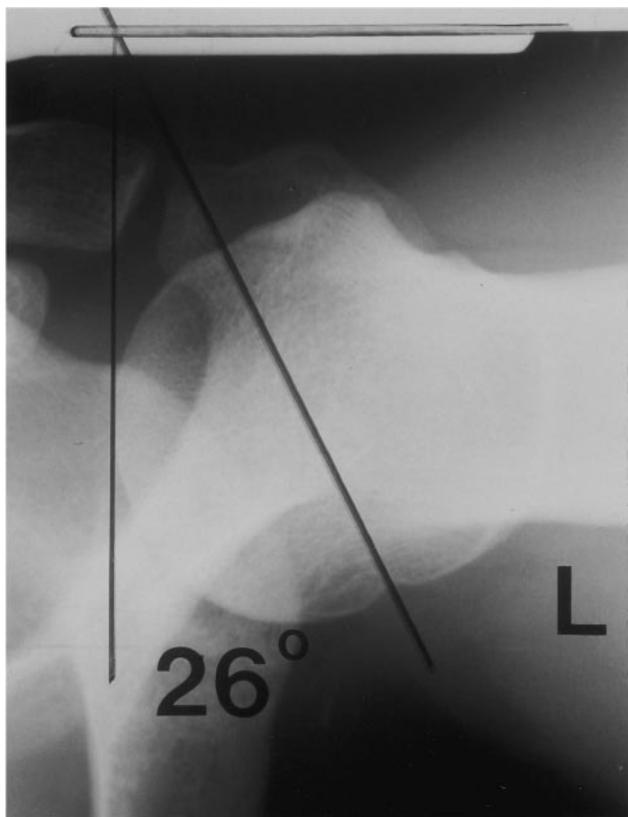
Axial view in a special radiographic technique.²⁵ Projected angle of humeral retrotorsion of the left (nondominant) shoulder in a right-handed handball player.
